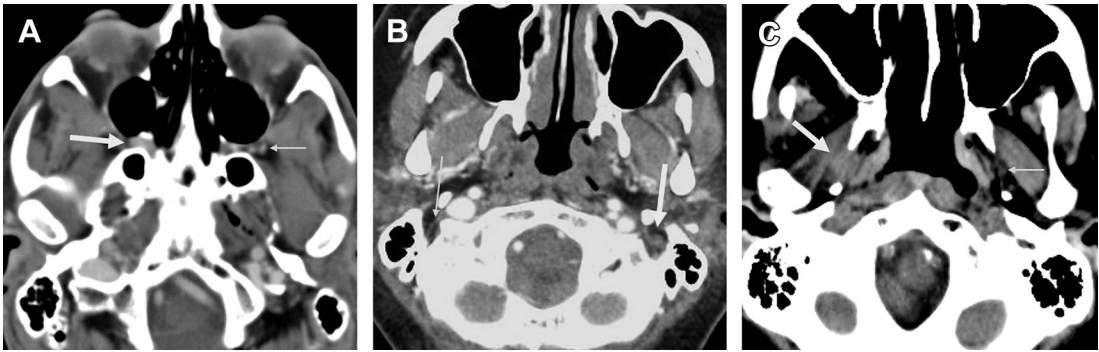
Most PNS extending to the skull base will involve 1 of the 3 sites shown. Because most nerves are surrounded by fat, which can be easily identified on CT, a careful scrutiny of common locations of PNS at the skull base will allow identification of PNS in most cases. Relatively subtle nerve enlargement and effacement of surrounding fat in the right PPF (A), left stylomastoid foramen (B), and right infratemporal fossa just below the foramen ovale (C) indicate PNS in these patients with palate adenocystic carcinoma, parotid mucoepidermoid carcinoma and oral tongue SCC, respectively (*thick arrows*). Thin arrows point to the normal contralateral nerves.
